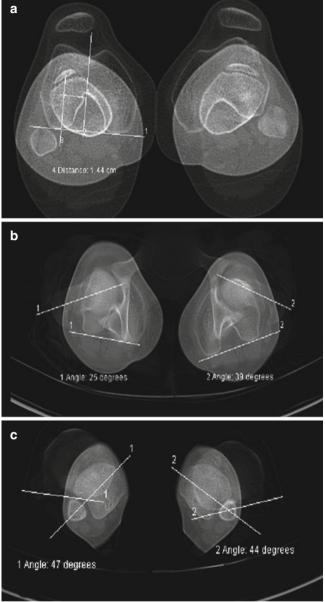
CT scan of the lower limbs assessing the TGTT distance (a), femoral torsion (b) and tibial torsion (c)
